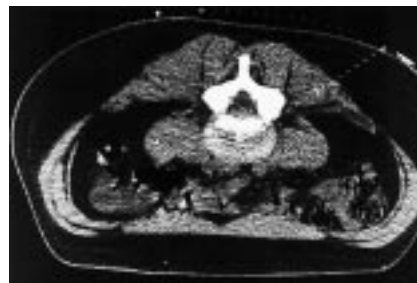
Unmagnified abdominal CT scan through the disk space. Computer-generated lines, available with all CT scanners, can be used to calculate the distance of the entry point from the midline and a path to the center of the disk. (Reproduced with permission from Onik G, Helms C (eds): *Automated Percutaneous Lumbar Discectomy*. San Francisco, Radiology Research and Education Foundation, 1988, p 81.)
